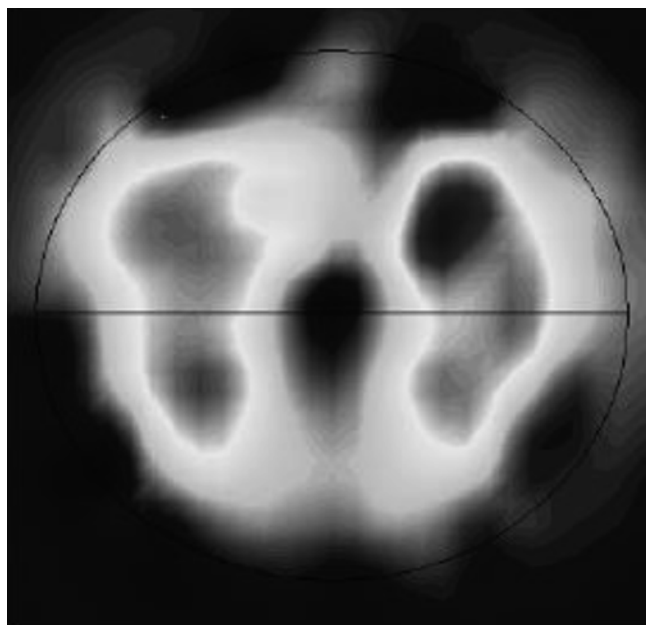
EIT image of the lung. The orientation is the same as for a CT image. Both lung fields show equal impedance change during spontaneous breathing (Adapted from Wolf and Arnold [96]. With permission from Springer Science+Business Media)
